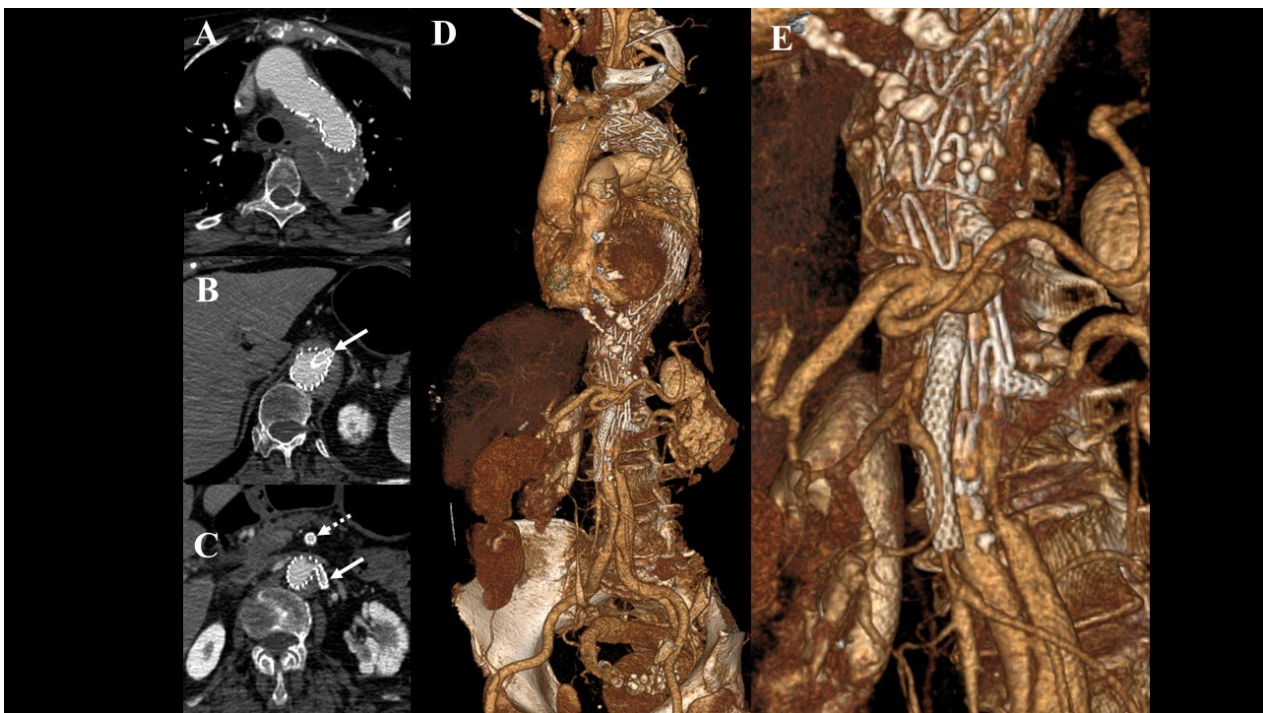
Preoperative work-up. Follow-up, preoperative computed tomography angiography showing the evolution of a chronic post-dissection aneurysm (A). Aortic disease extent was type C (B), with the celiac trunk, the left renal artery and the inferior mesenteric artery originating from the false lumen (FL), and the superior mesenteric artery as well as the right renal artery from the true lumen (TL) (C).
